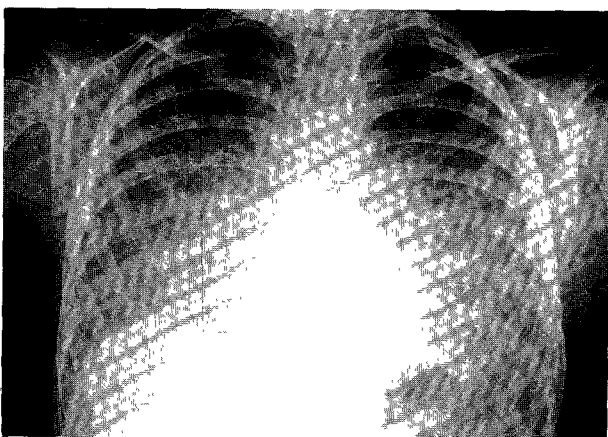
Chest X-ray of case 1 showing bilateral diffuse ground-glass opacity.
